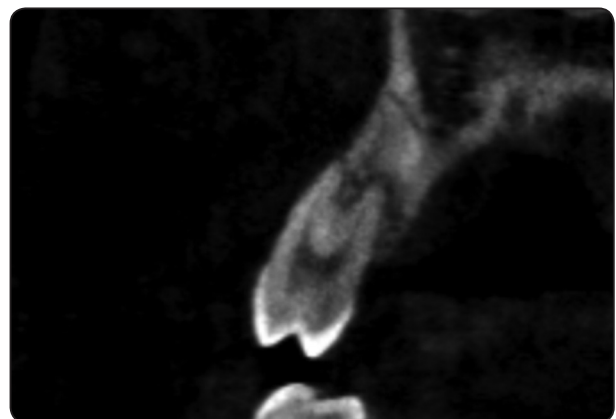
Coronal CBCT image showing dehiscence of buccal bone in the cervical, middle, and apical thirds of the right second premolar.
